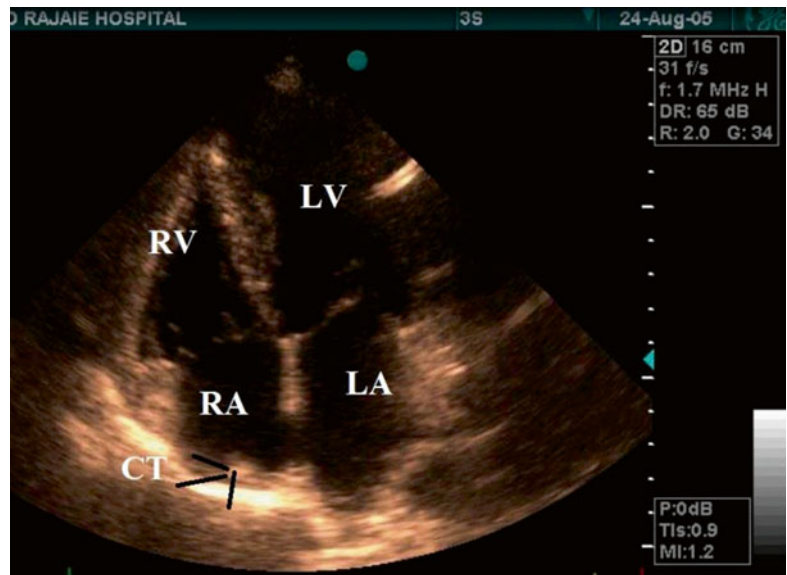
Crista terminalis (arrow) in four-chamber view in transthoracic echocardiography. LV left ventricle, RV right ventricle, RA right atrium, LA left atrium, CT crista terminalis
